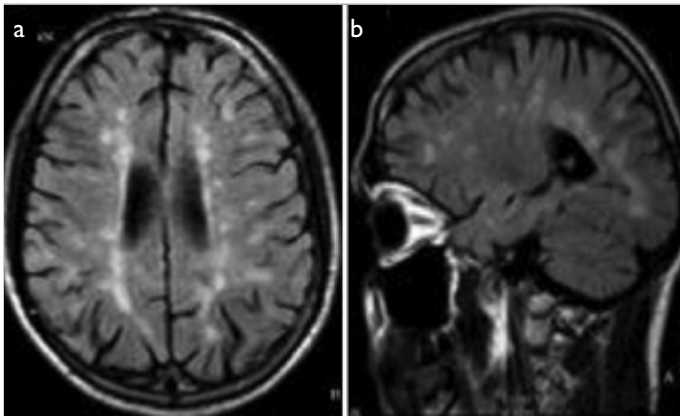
a, b. Axial T2 Fluid-attenuated inversion recovery (FLAIR) image (a) at the level of lateral ventricles showing hyperintense periventricular white lesions suggestive of MS and parasagittal T2 FLAIR image (b) showing multiple, ovoid-shaped hyperintense periventricular white lesions
